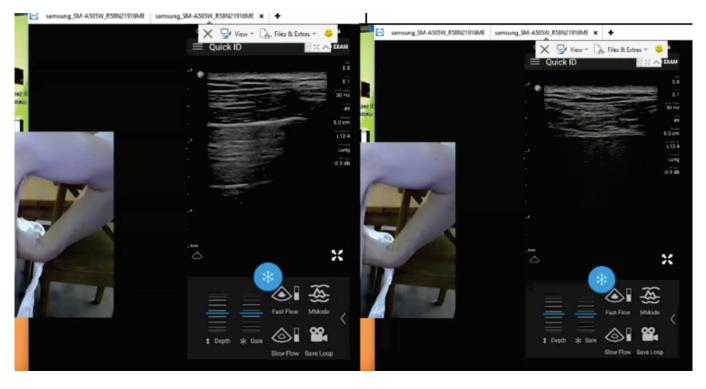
Example of Ultrasound Naïve Volunteer being guided to image their own chest. Figure Legend: Screenshot of the Mentors computer in Calgary viewing the completely novice self-isolating volunteer image their upper right anterior lung field depicting the visceral and parietal pleural interface with movement emphasized with Color Power-Doppler the "Power-Slide" Sign (seen in Supplementary Materials). Note: Lung ultrasound is a dynamic science much better appreciated with real time imaging. The videorecording of the entire mentored Lung examination ca be viewed in Supplementary File S1.
